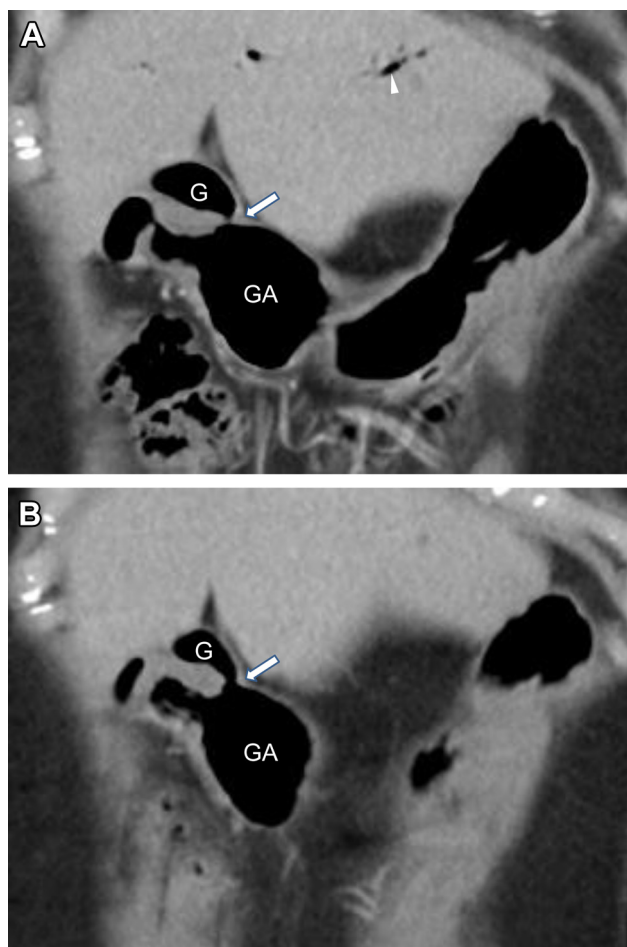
(A, B) Two contiguous reformatted coronal images on first follow-up CT examination 1-year after lower anterior resection of sigmoid colonic carcinoma showed the vertically oriented air-distended fistula (arrow) between the gall bladder (G) and gastric antrum (GA) with pneumobilia (arrowhead).
